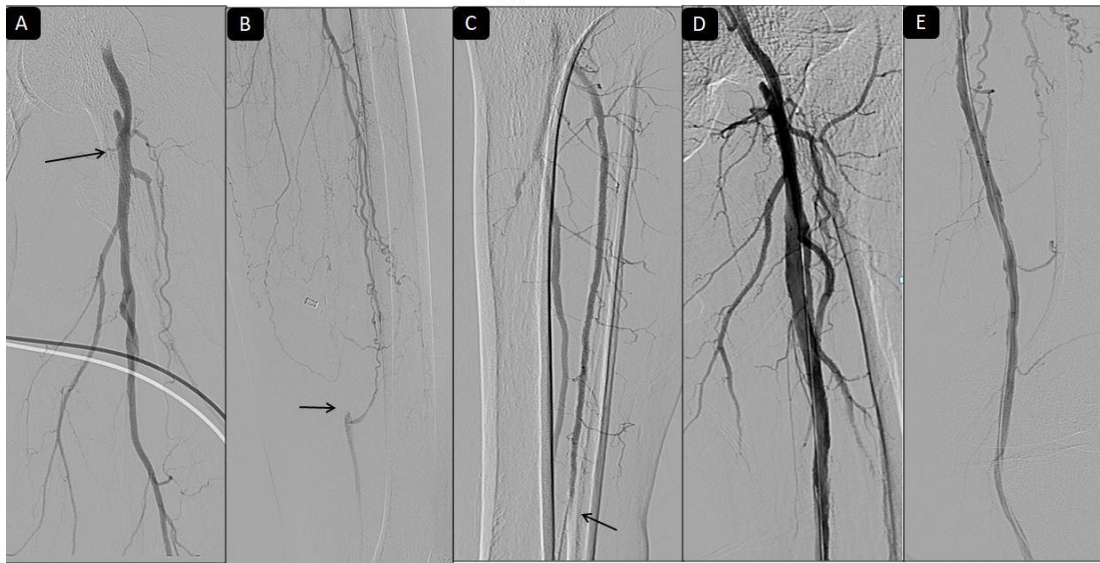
17 A) CTA revealed TASC C femoropopliteal disease on right side. B) Left CFA retrograde approach with cross over sheath angiogram showed occlusion of proximal and mid SFA (arrow in B) with reformation at the adductor canal (arrow in B). C) Subintimal angioplasty performed using a 6mmx10cm balloon with good opening of the occluded segment and good distal flow (D).
